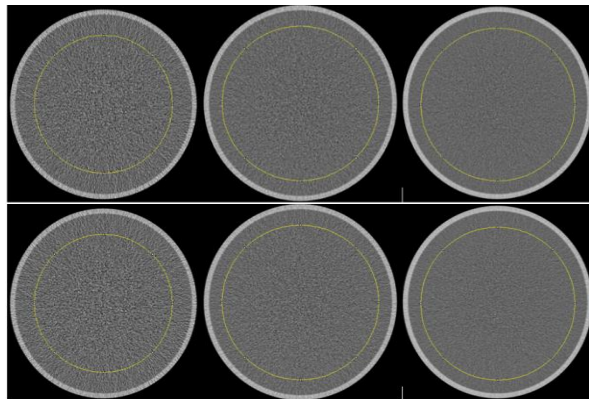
CT images obtained at the facilities.
